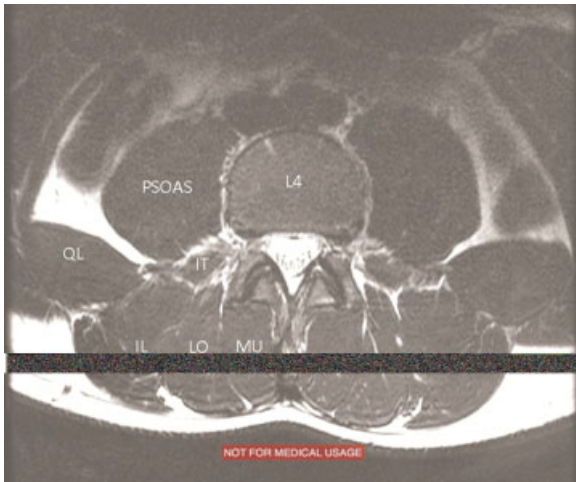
Axial T-2 weighted magnetic resonance image at the L4 vertebral body level showing the psoas (PSOAS), the multifidus (MU), iliocostalis (IL), longissimus (LO), quadratus lumborum (QL), and intertransversarii (IT) muscles.
